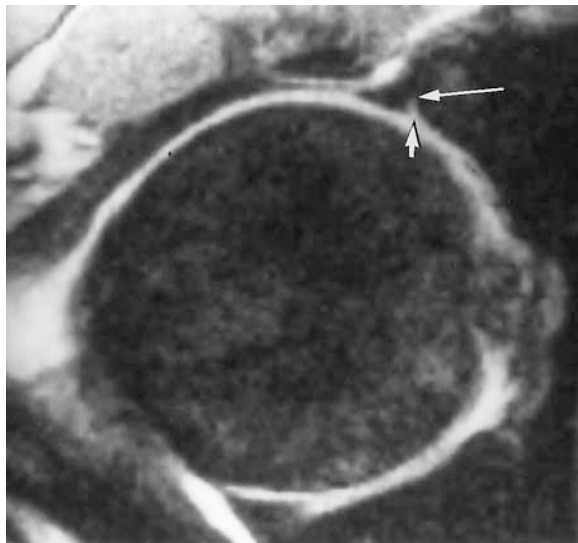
Hip pain for 19 months after a motor vehicle accident in a 29-year-old woman. T1-weighted (600/17) sagittal MR image obtained with intraarticular contrast material reveals an absent anterior labrum (arrow).
